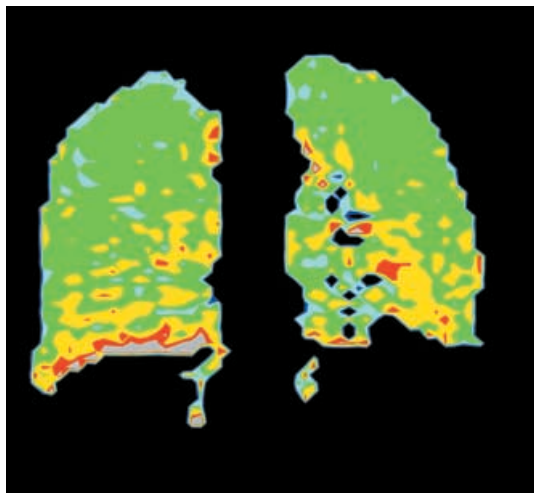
Color-coded oxygen-sensitive He-3 MRI after inhalation of hyperpolarized He-3 gas in a 31-year-old male volunteer with a mean end-expiratory, i.e., alveolar, oxygen pressure of 127 mm Hg showing a homogeneous distribution with values of 100–160 mm Hg
